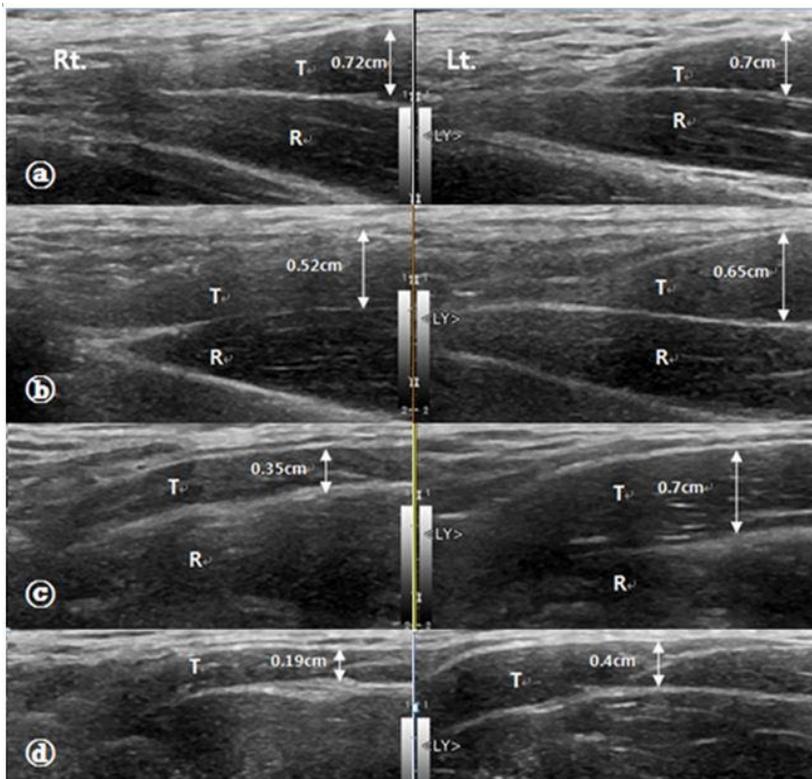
Ultrasonography showed atrophy of middle and lower component of the trapezius.
